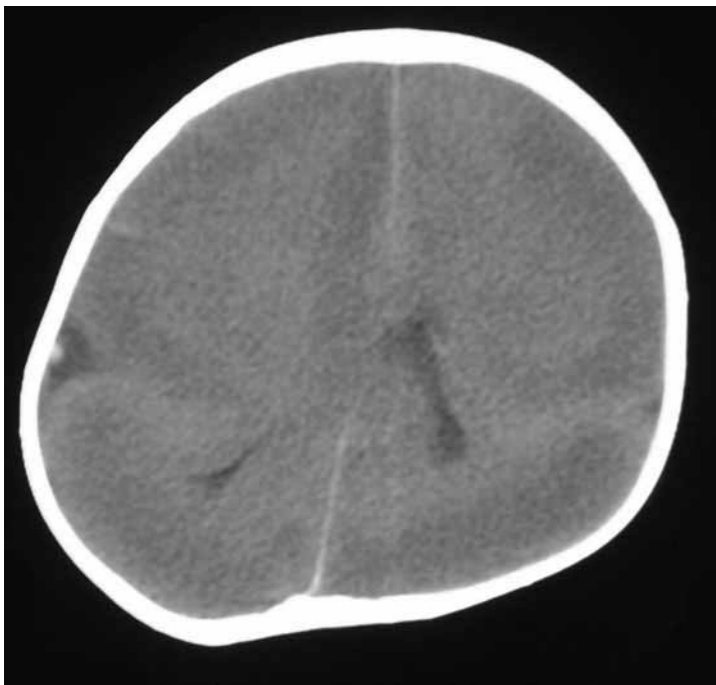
An MRI scan of an individual with lissencephaly, which literally means smooth brain. Patients with this disease, lack the characteristic folds in the cortex, and often exhibit learning disabilities with epilepsy.
